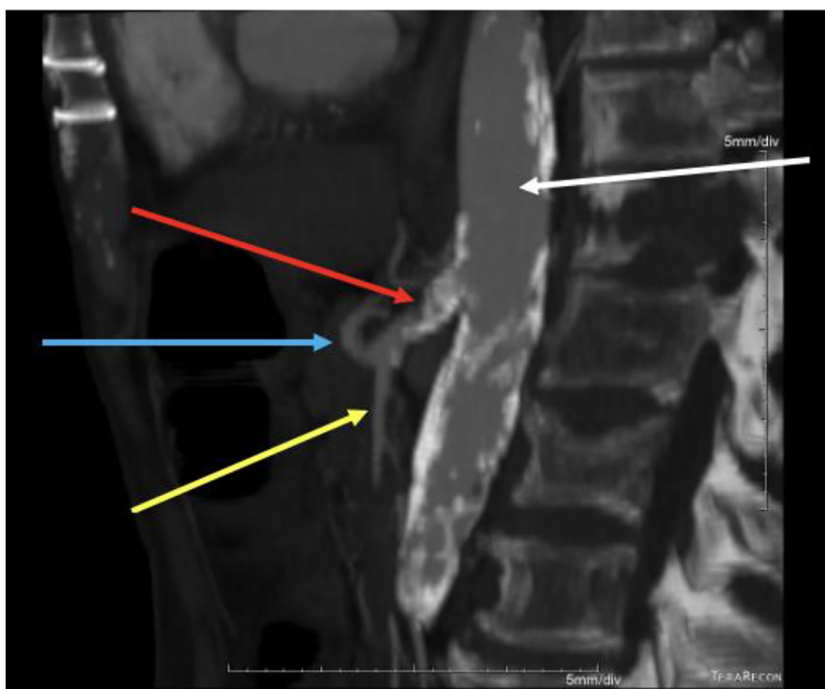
Contrast computed tomography of the abdomen and pelvis on hospital day 2 showed occlusive atherosclerotic disease at the origin of a combined celiac/superior mesenteric artery trunk (red arrow). The white arrow denotes the aorta, the blue arrow denotes the celiac artery, and the yellow arrow denotes the superior mesenteric artery.
